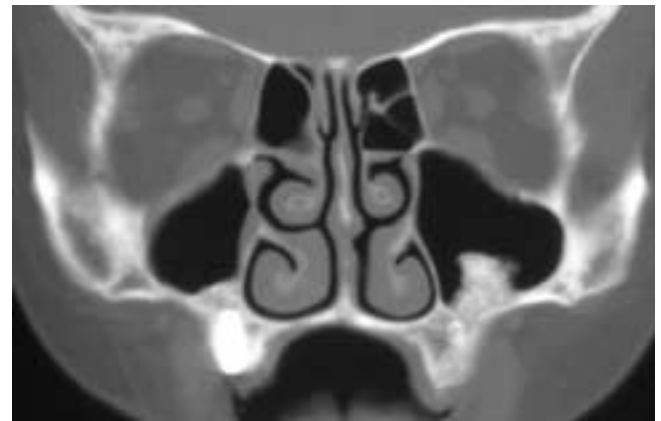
Coronal CT scan shows a dental implant in the right maxillary alveolus. In the floor of the left antrum, there is a bony prominence that represents transplanted bone placed to support a future left-sided dental implant.
